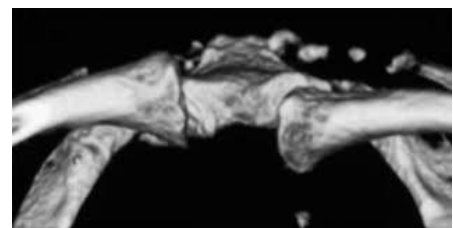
CT with 3D reconstruction demonstrating posterior SC dislocation.
